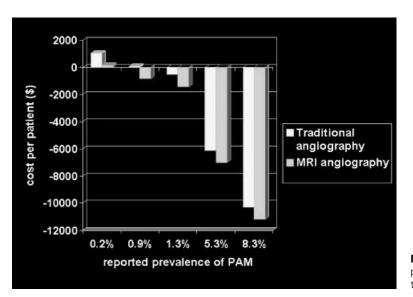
Calculated excess cost or savings per patient to avoid this complication, using traditional angiography vs. MRI angiography.
